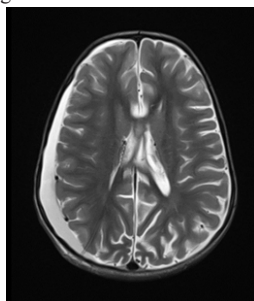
Subdural collection: Axial T2w MRI image show extra axial fluid collection along right fronto-temporo-parietal region.
